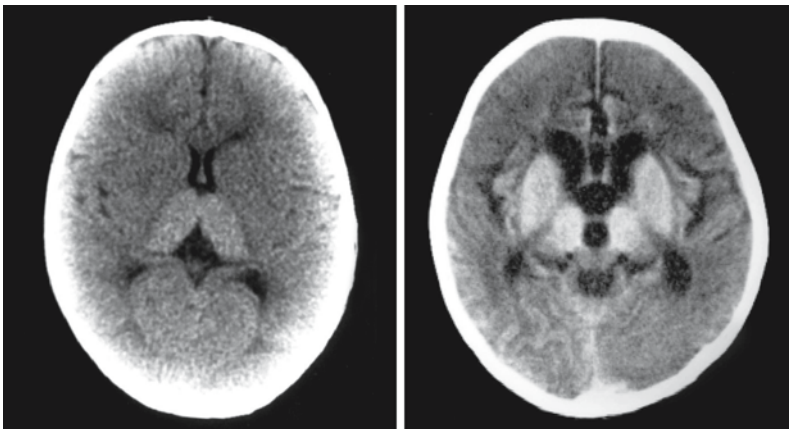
The CT scan of a 12-month-old girl with SD (*left*) shows the hyperdensity of the thalamus on both sides. From Brismar et al. (1990), with permission. The CT scan of a 5-year-old child with TSD (*right*) shows hyperdensity of thalamus, globus pallidus, putamen, and caudate nucleus, together with some diffuse white matter hypodensity and cerebral atrophy. From Fukumizu et al. (1992), with permission
